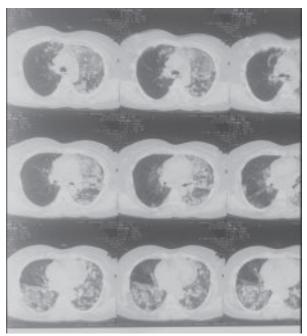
HRCT Chest of the patient
